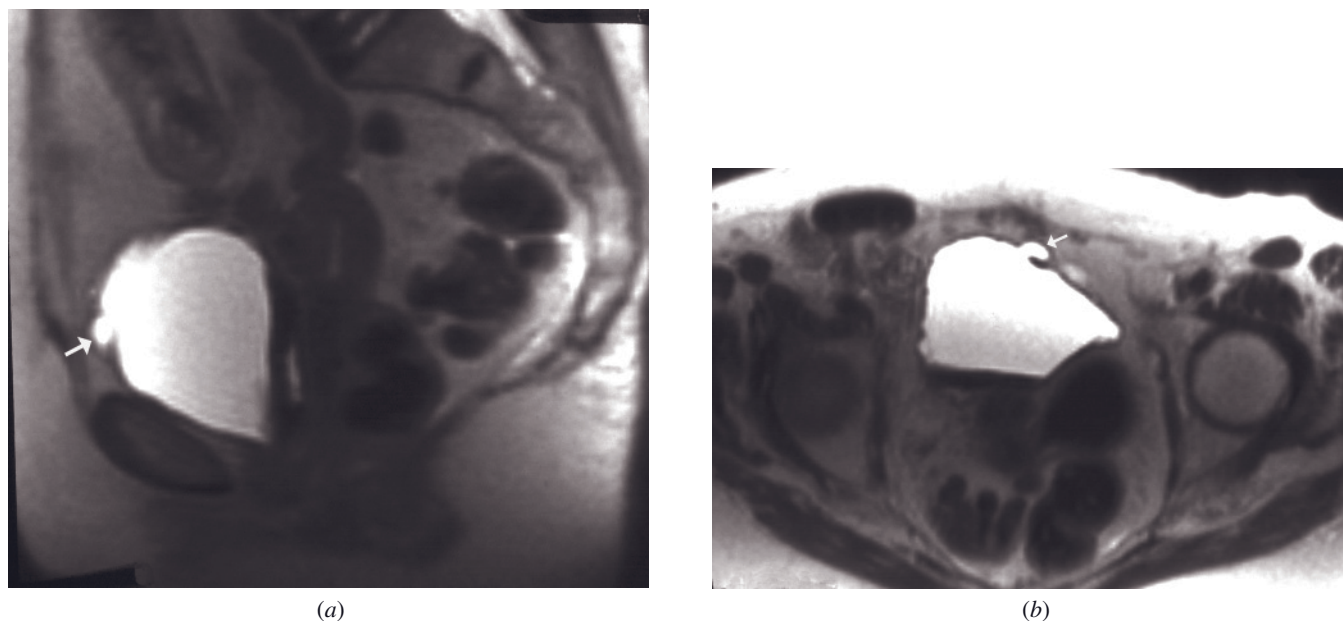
Bladder diverticula. Sagittal (a) and transverse (b) T2-weighted SS-ETSE images demonstrate focal outpouchings of the bladder representing diverticula (arrows, a, b).
